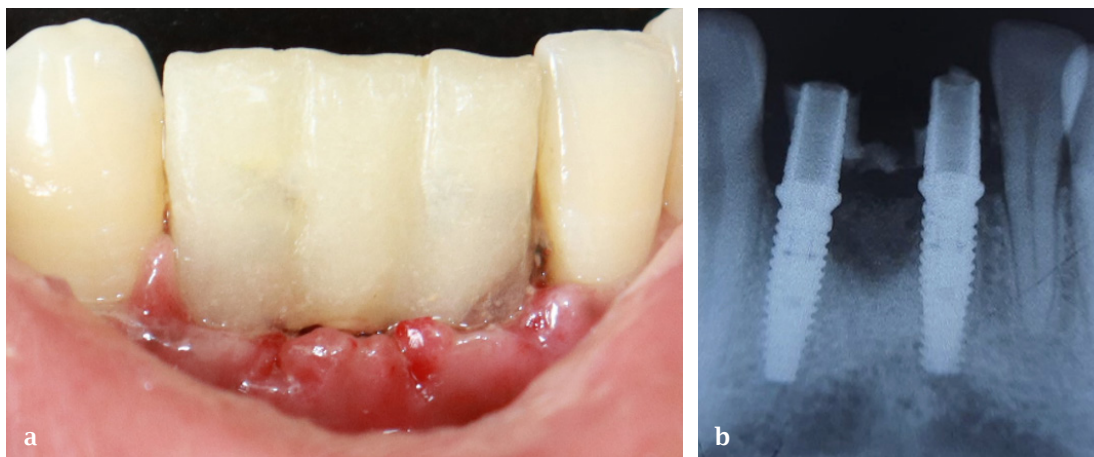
a) Immediate temporary resin prosthesis; b) Post-operative intraoral periapical radiograph.
